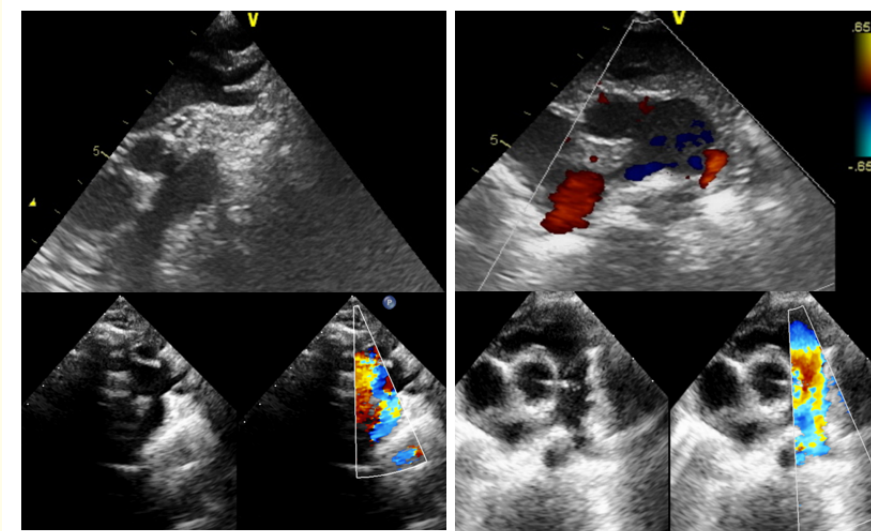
Preoperative and postoperative cardiac doppler ultrasound demonstrating the repair in terms of anatomy and hemodynamically reflected by the elevated pulmonary hypertension previously caused by the APW.
